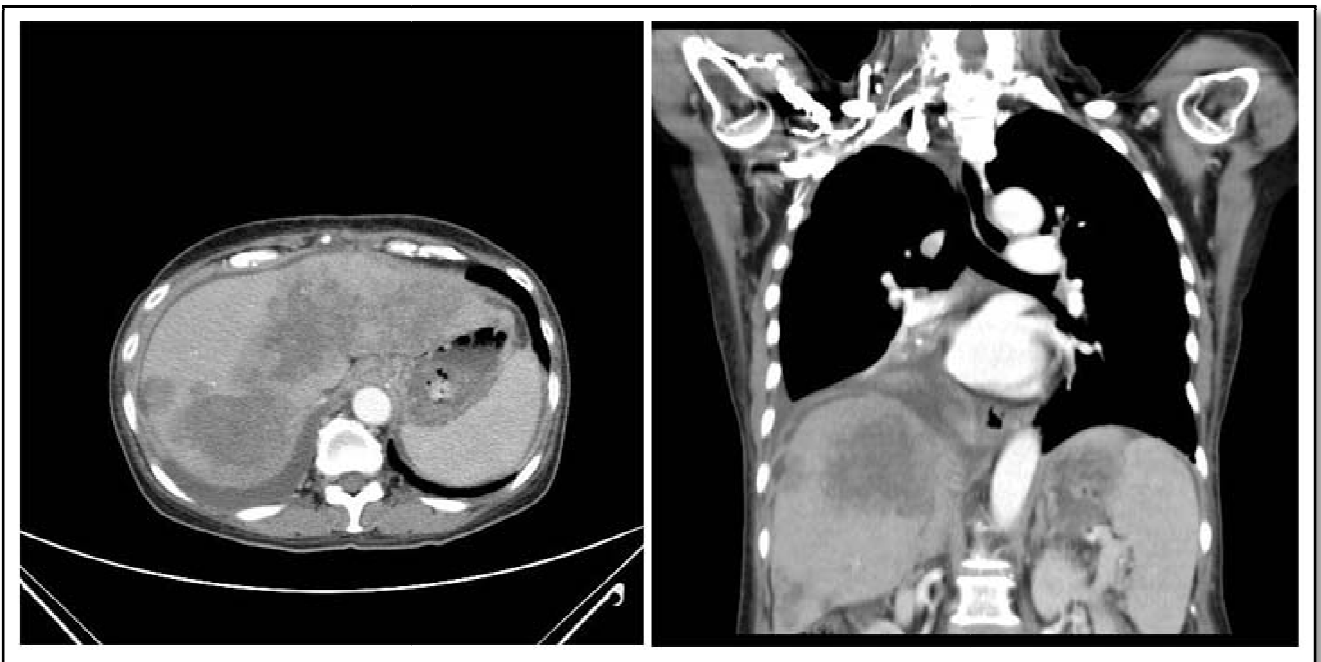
(c)Postenhanced CT demonstrated the large metastases at liver.
